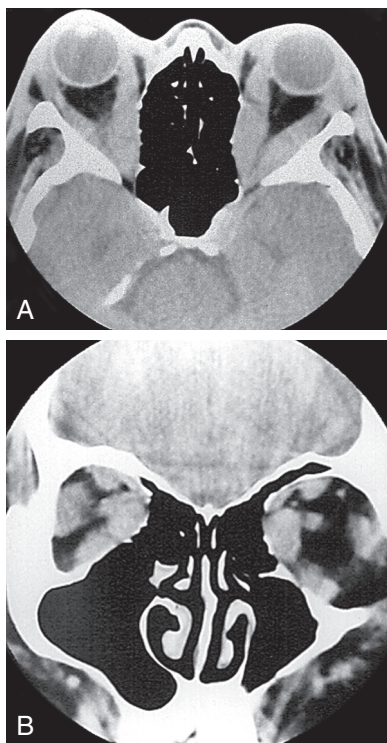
Axial A, and coronal B, computed tomographic scans showing enlargement of all four rectus muscles.
